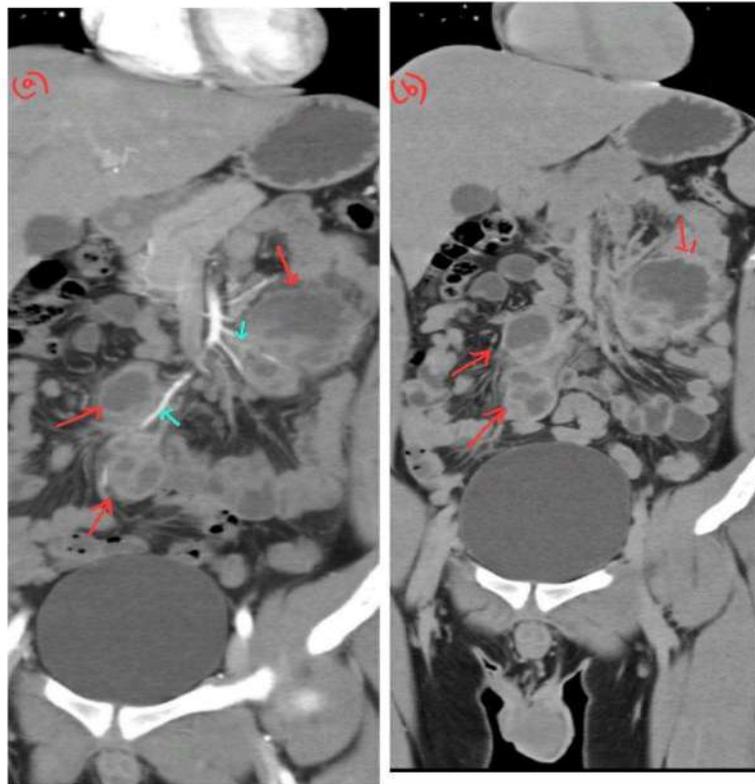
a) Contrast enhanced CT abdomen showing 7*5*4 cm multiloculated cystic mesenteric lesion, with thick septations on left side of abdomen (red arrow on left), the jejunal branches of the superior mesenteric artery being involved (blue arrow on left). 7*4*3.5 cm multiloculated mesenteric cyst on the right side of the abdomen (red arrows on right), the cystic lesion is saddling the ileocolic branch of the superior mesenteric artery. b) CT abdomen without contrast.
